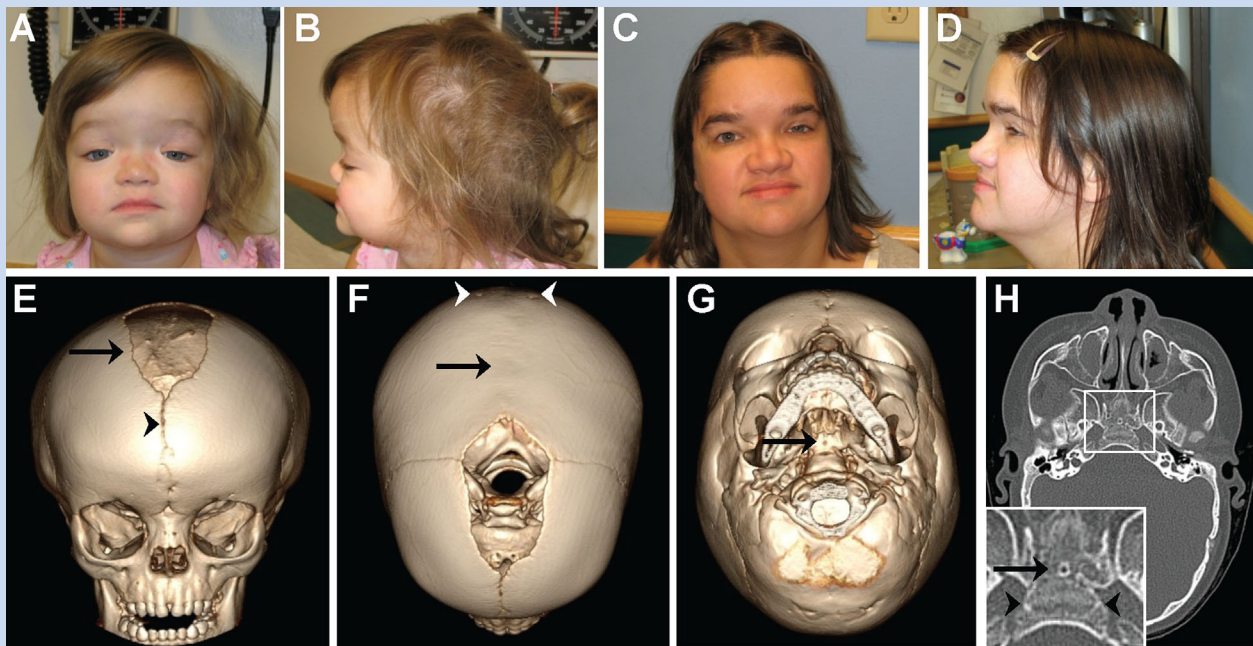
Frontonasal dysplasia phenotype. A–B: Facial features of the proband at 21 months of age, including high hairline, frontal bossing, hypertelorism, ptosis, and broad nasal tip. C–D: Facial features of the proband's mother as an adult, including high frontal hairline, frontal bossing, hypertelorism, unilateral ptosis, broad nasal tip, and prognathia. E–H: Cranial CT 3D reconstruction for the proband at 31 months of age demonstrating wide anterior fontanelle [E, arrow], metopic synostosis [E, arrowhead], parietal foramina [F, arrowheads], sagittal synostosis [F, arrow], persistent craniopharyngeal canal [G and H, arrow], and premature lateral spino-occipital synchondrosis [H, arrowheads].
